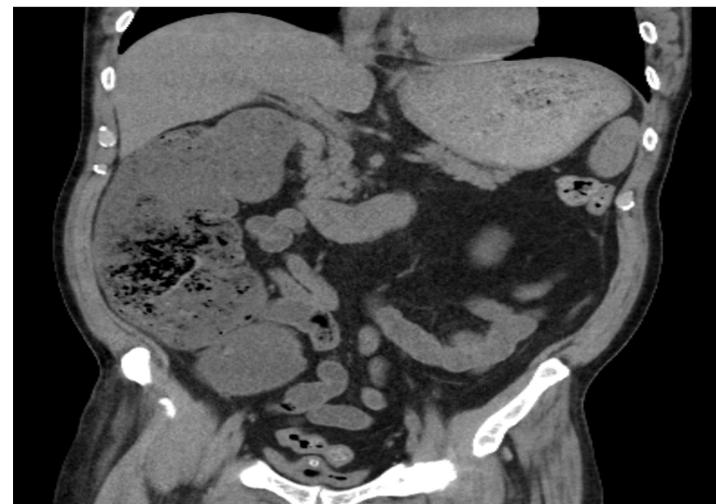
CT abdomen/pelvis showing severe dilation of the right hemicolon and stomach with significant periportal stranding. No obvious pneumoperitoneum.
